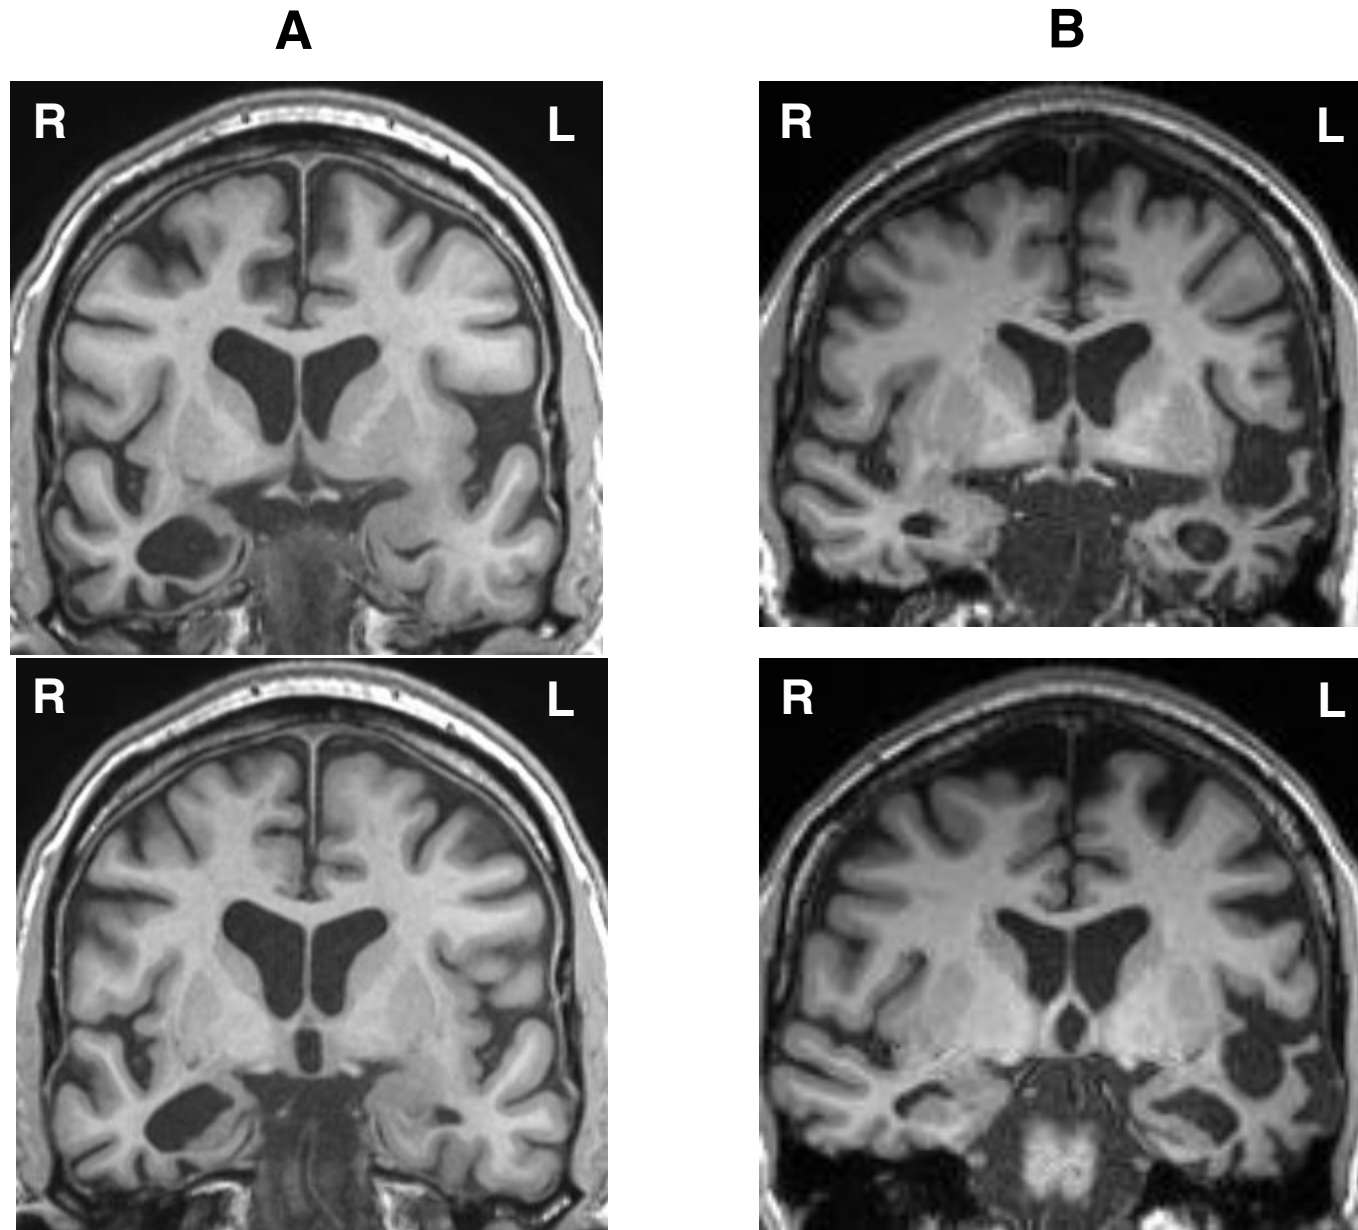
MRI characteristics in right temporal variant FTLTD vs semantic variant PPA
